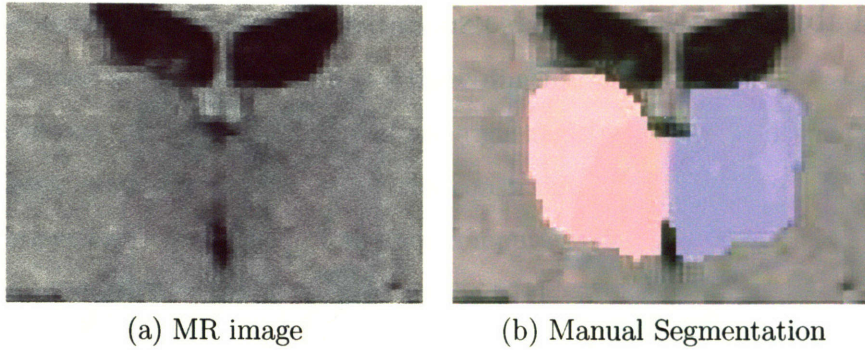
(a) shows a MR image of the area around the thalamus, which is this image the structure below the dark ventricles. The corresponding manual segmentation of the thalamus is shown in (b). From the intensity pattern in (a) the boundary of the thalamus to the neighboring white matter is not clearly defined.
